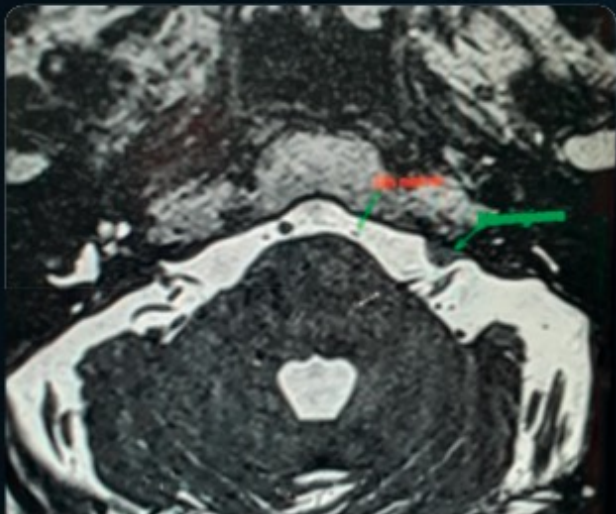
High resolution T2W MRI axial
